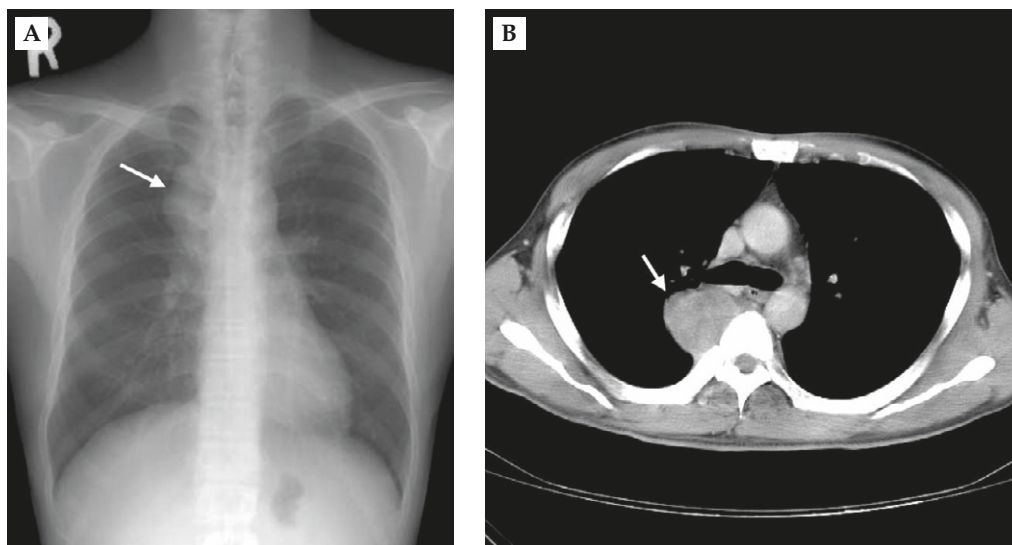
(A) Chest X-ray revealed a well-defined soft tissue mass in the right posterior mediastinum (arrow). (B) Chest computed tomography revealed a $3.7 \times 4.3 \times 6$ cm heterogeneous contrast-enhanced soft tissue mass in the right paraspinal region of T5 (arrow).
